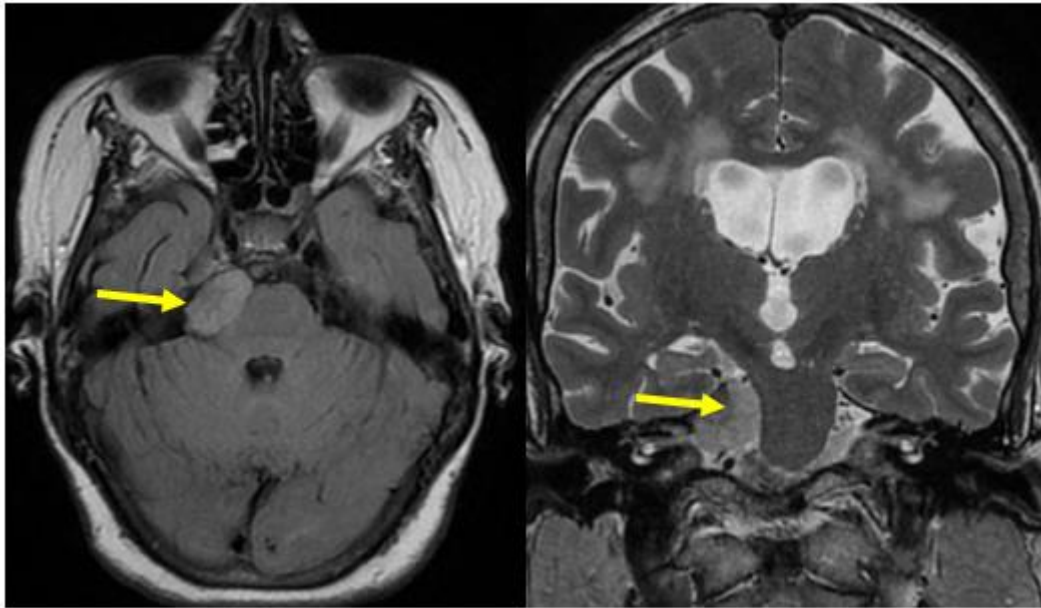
Axial T1-weighted and coronal T2-weighted brain MRI demonstrating the lesion (yellow arrow) within the right cerebellopontine angle, centered on the cisternal segment of the right trigeminal nerve, with infiltration of the right Meckel's cave and a mass effect on the pons causing medial displacement
